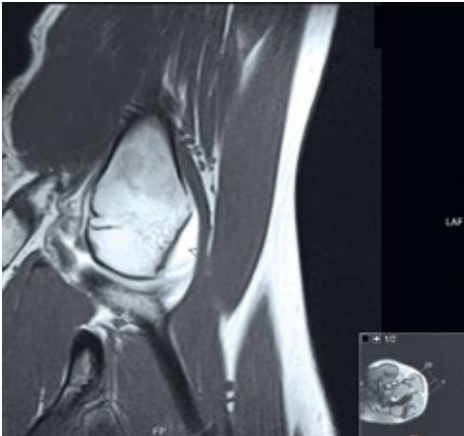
Example of a Hill-Sachs lesion (arrow) (ABER position orientation, T1-weighted): posterior-lateral bone defect of the humeral head
